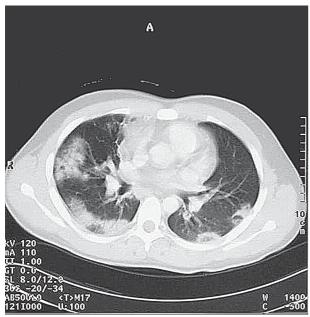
Chest CT with contrast enhancement disclosed multifocal subpleural areas of air space consolidation and a confluent heterogeneous soft-tissue mass in the the prevascular space of anterior mediastinum, demonstrating residual Hodgkin's lymphoma (lung window).
